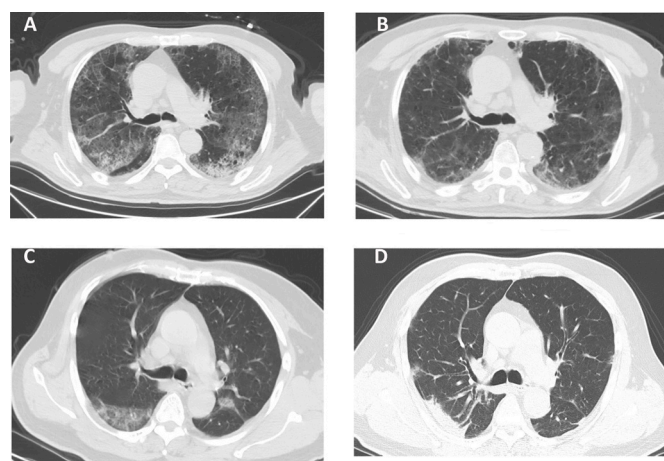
Chest computed tomographic manifestations at enrolment and after treatment.
